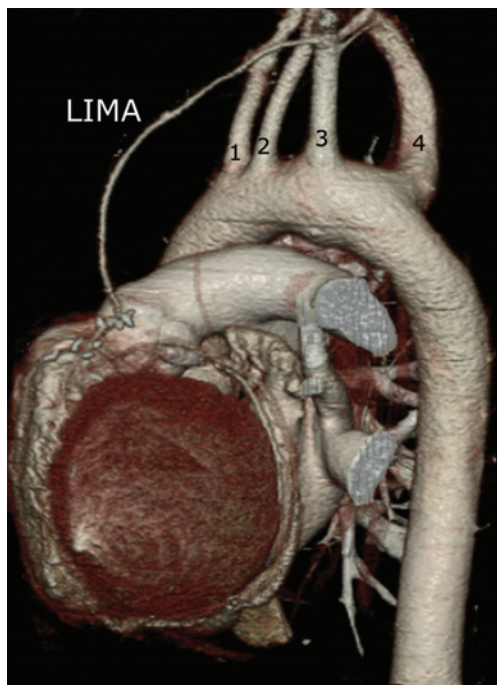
An aberrant right subclavian artery (4) may have a remarkable size, which may lead to difficulties in positioning the intra-aortic balloon with echocardiography because the guide wire may deviate. The number 1 indicates the right carotid artery; 2, left common carotid artery; 3, left subclavian artery. Postoperative 16-multidetector computed tomography scan was performed to assess left internal mammary artery (LIMA) graft patency. The image is 3-dimensionally displayed by applying a volume-rendering technique.
